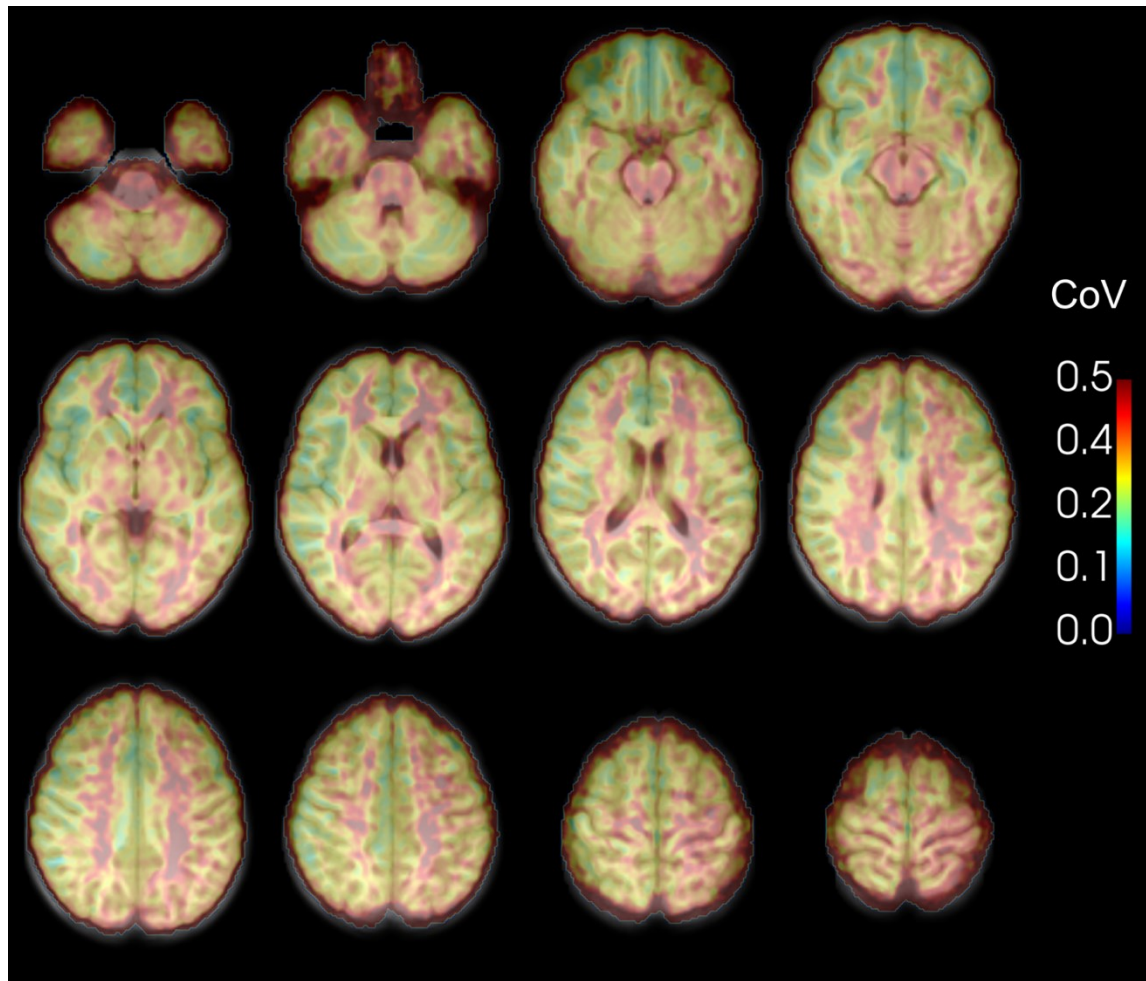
Population PCASL₃PLD CoV map overlaid on the population T1-weighted image.
